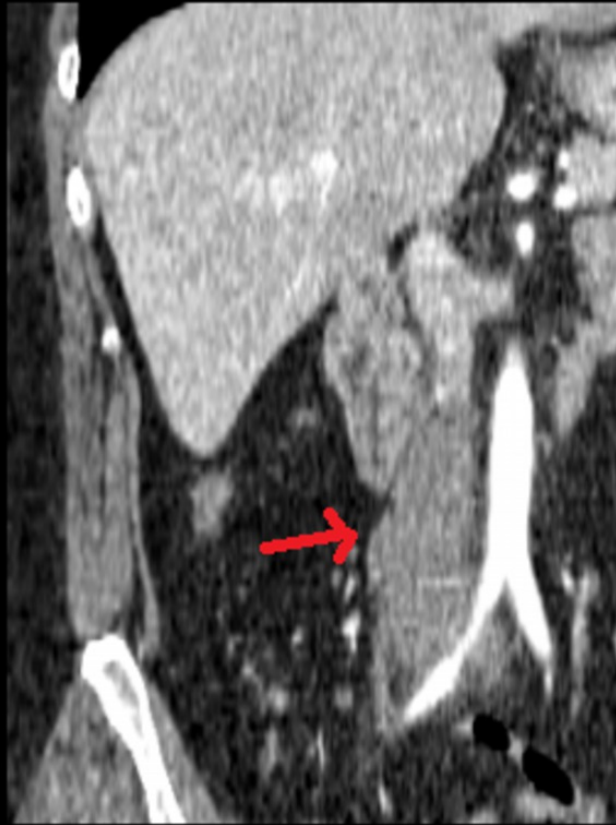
IVC filter removal complication: This patient had left lower extremity thrombosis and was placed an IVC filter below the renal veins level. Coronal enhanced computed tomography, after the IVC removal, shows a large filling defect in the infrarenal IVC (red arrow), with extension to the common iliac vein, right common and superficial veins.
